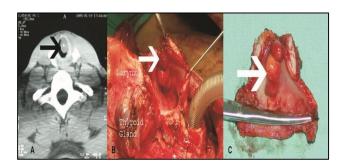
(A-C): CT scan showing the tumor in the cricotracheal region. Tracheostomy up to the carina after cutting into the thyroid gland. Resected tumor.
